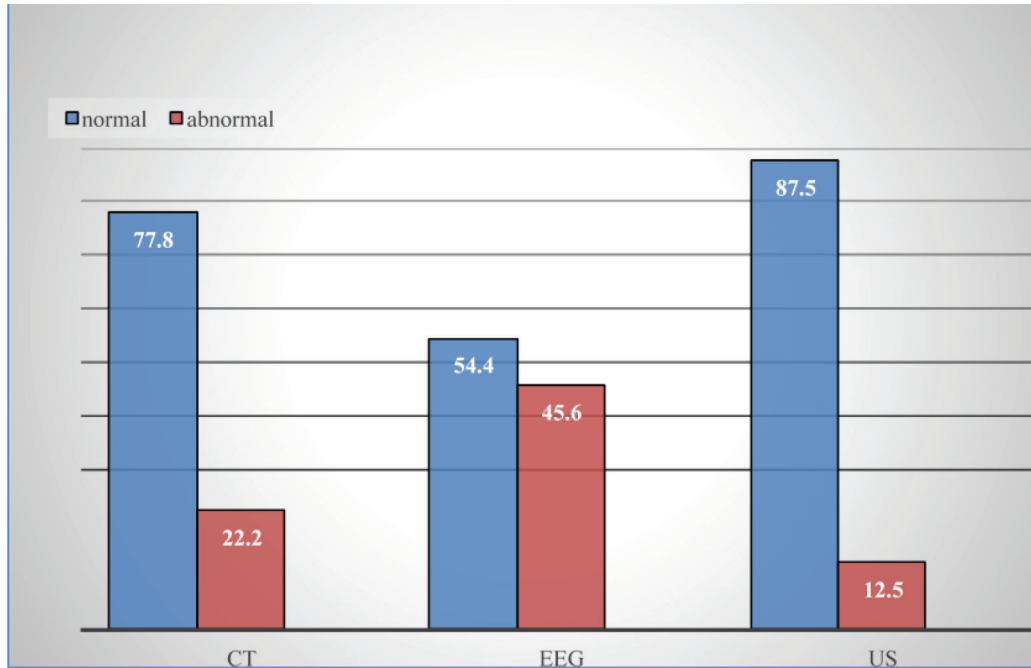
Rate of abnormal findings in CT, EEG and US in neonatal seizure
